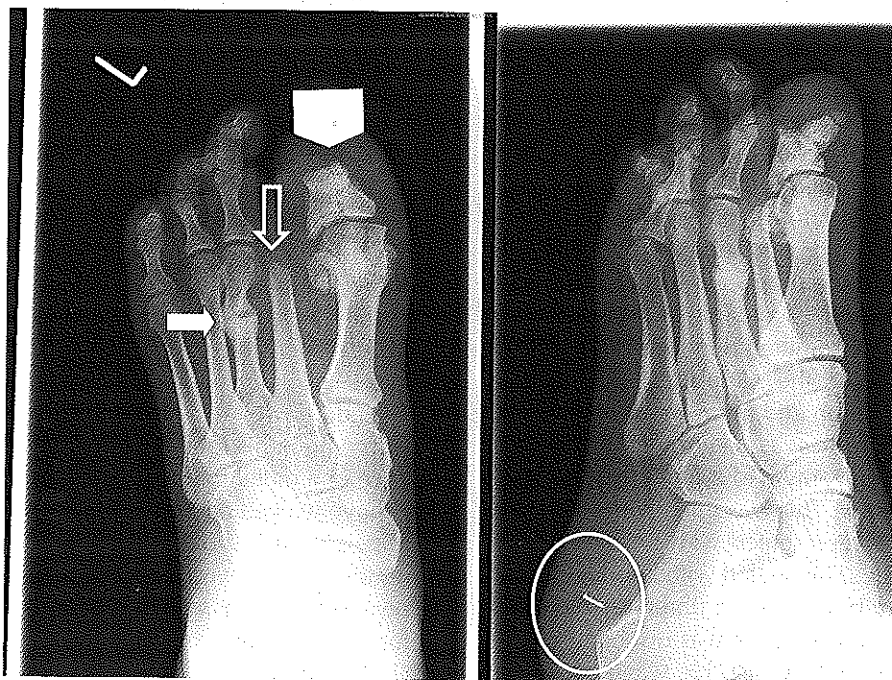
Radiograph of left foot, showing evidence of a healed fracture of the shaft of the third metatarsal (solid arrow), previous amputation of the distal phalanx of the first toe (large arrow head) and second toe (open arrow), and a metallic foreign body (circled).
